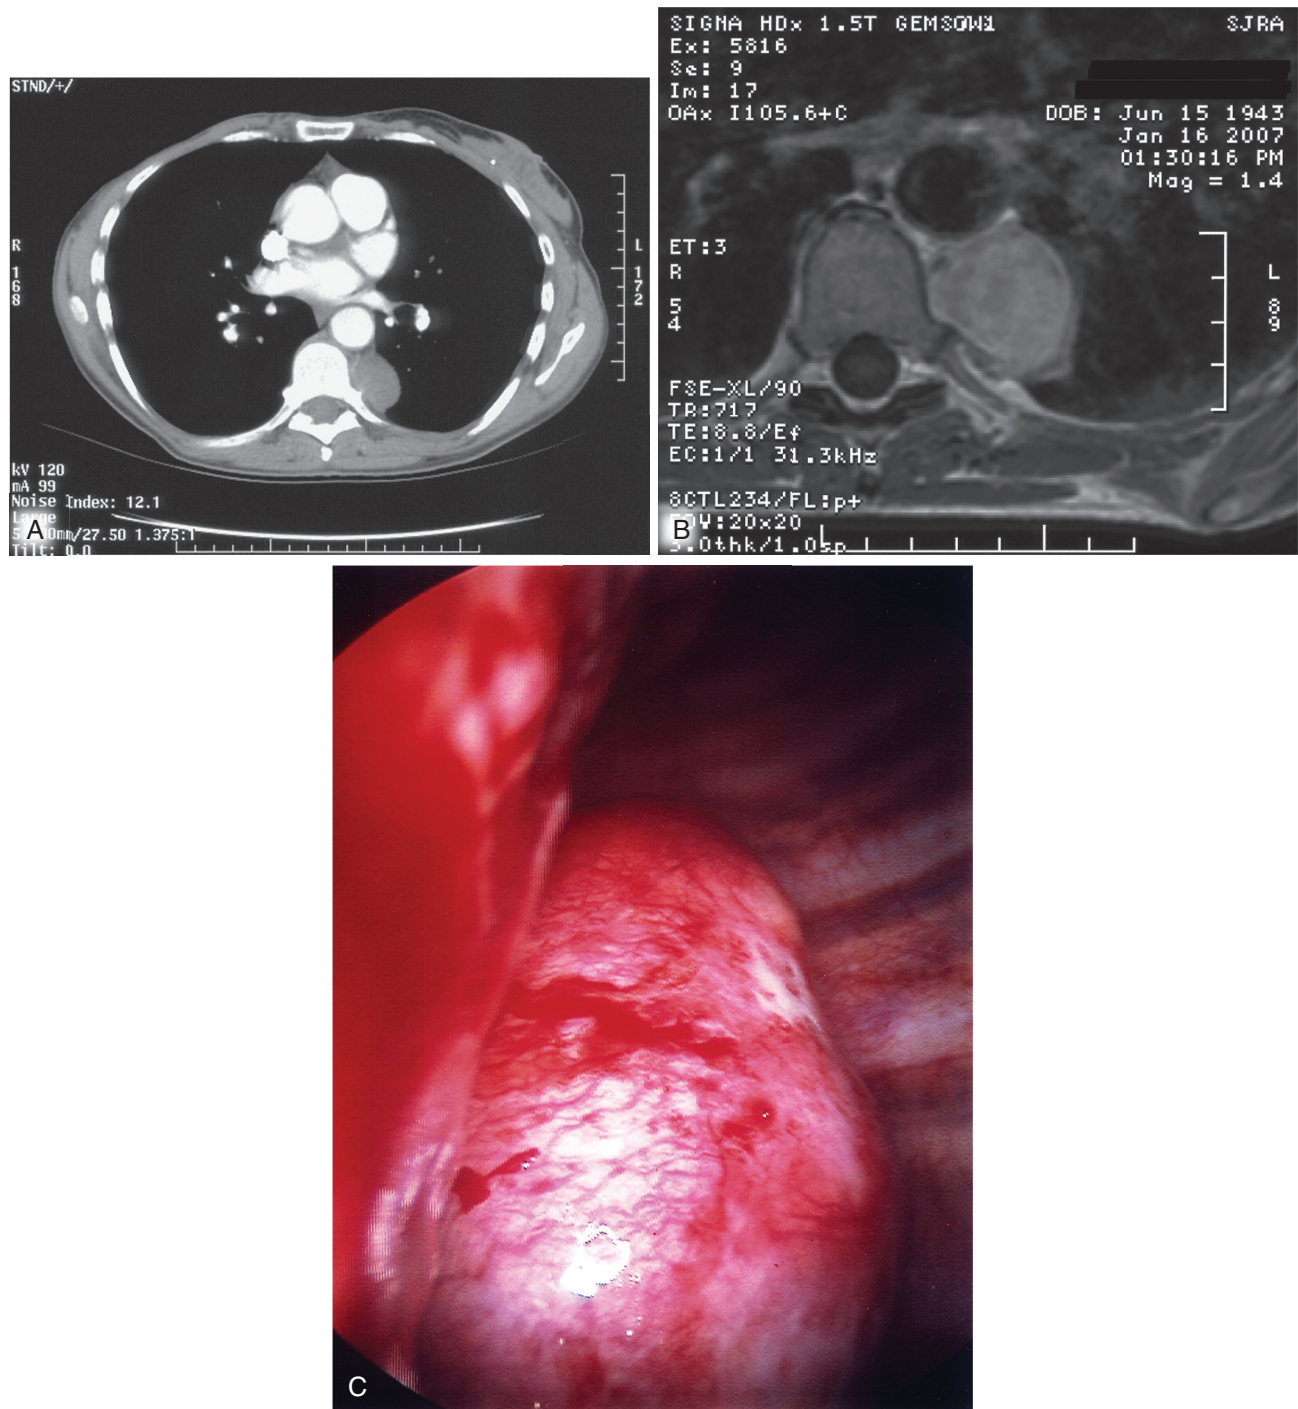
■ A, Axial CT image demonstrating a ganglioneuroma. B, The same lesion as seen on MRI. C, Intraoperative photograph of a ganglioneuroma as seen through the thoracoscope. (Courtesy Dr. John Kucharczuk.)
